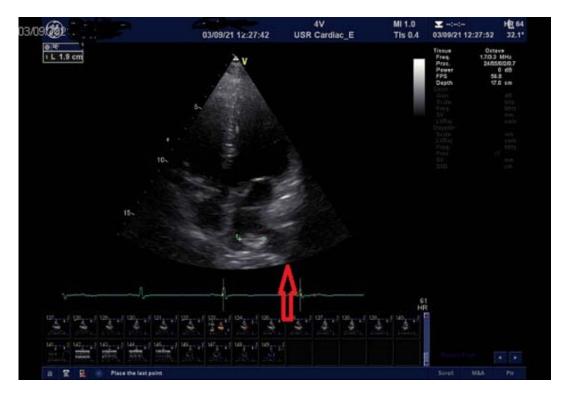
Thrombus migrating from the left inferior pulmonary vein into the posterior aspect of the left atrium on apical four-chamber view (arrow).
